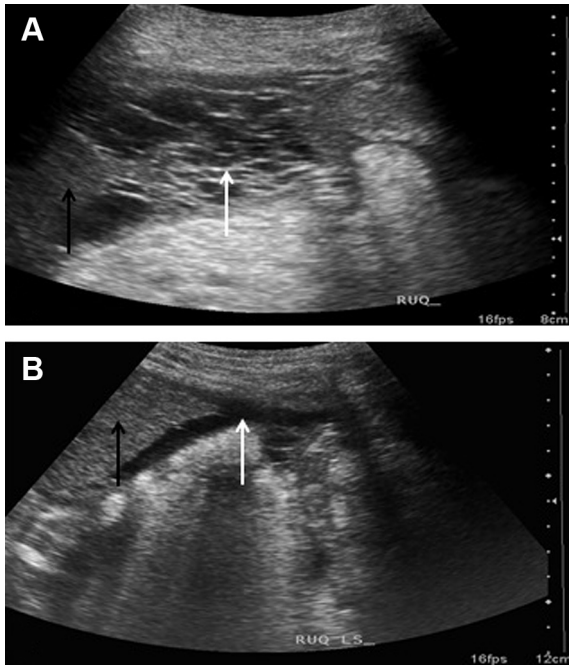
(A) Longitudinal ultrasound scan through the right upper quadrant demonstrating dense loculated ascites with a honeycomb appearance (white arrow) and inferior liver (black arrow). (B) Longitudinal scan of the right upper quadrant on Day 5 on fibrinolysis showing liver (black arrow) and minimal residual ascites (white arrow).
